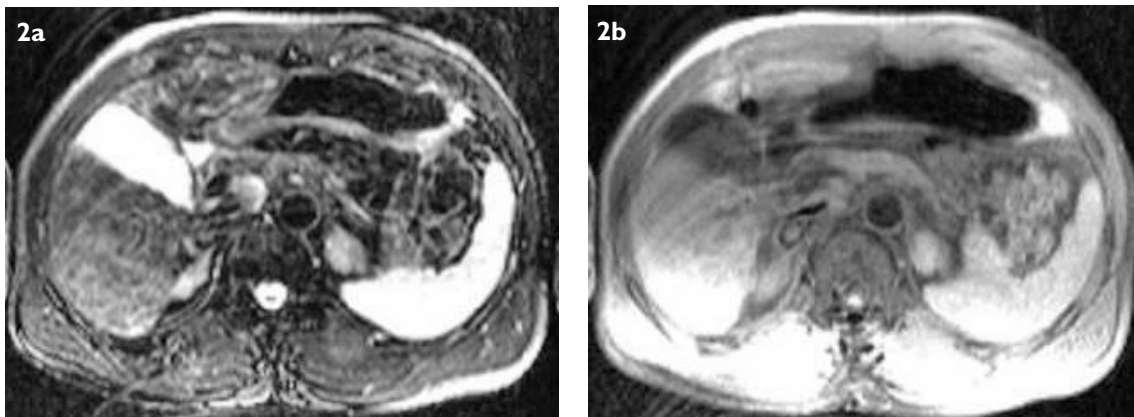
Axial (a) fat-suppressed T2-W, and (b) fat-suppressed T1-W MR images taken at the same level after six cycles of chemotherapy show near-complete regression of the hepatic mass.
